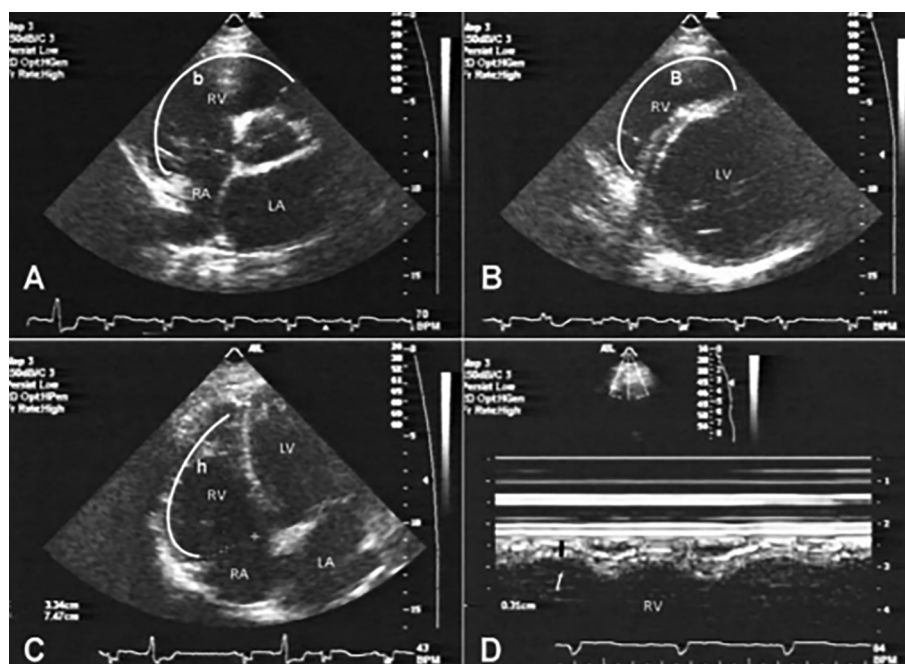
Measurement of the endocardium using the three segments method: a — parasternal position along the short axis at the level of the aortic valve; b — parasternal position along the short axis at the papillary muscle level; c — apical four-chamber position; d — measurement of pancreatic thickness in M-mode. RA — right atrium; LA — left atrium; RV — right ventricle; LV — left ventricle [6]
